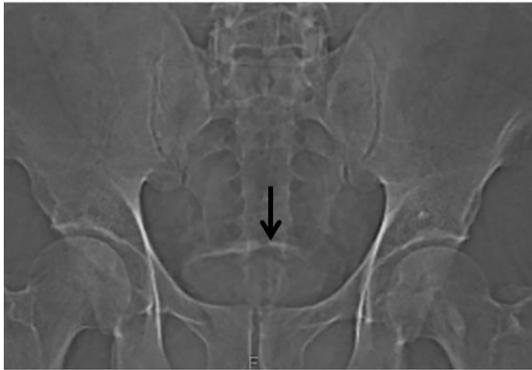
Fetal head calcification of Schistosomiasis. Frontal plain radiograph of pelvic region reveals curvilinear diffuse calcification outlining the urinary bladder (black arrow).
